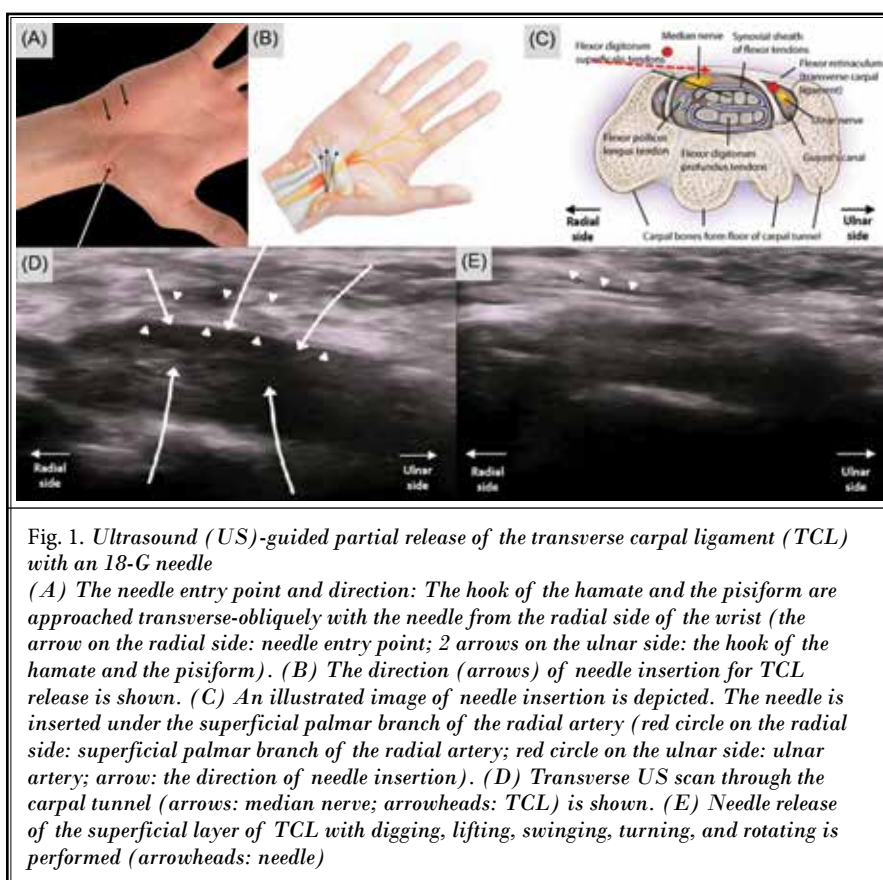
Ultrasound (US)-guided partial release of the transverse carpal ligament (TCL) with an 18-G needle
